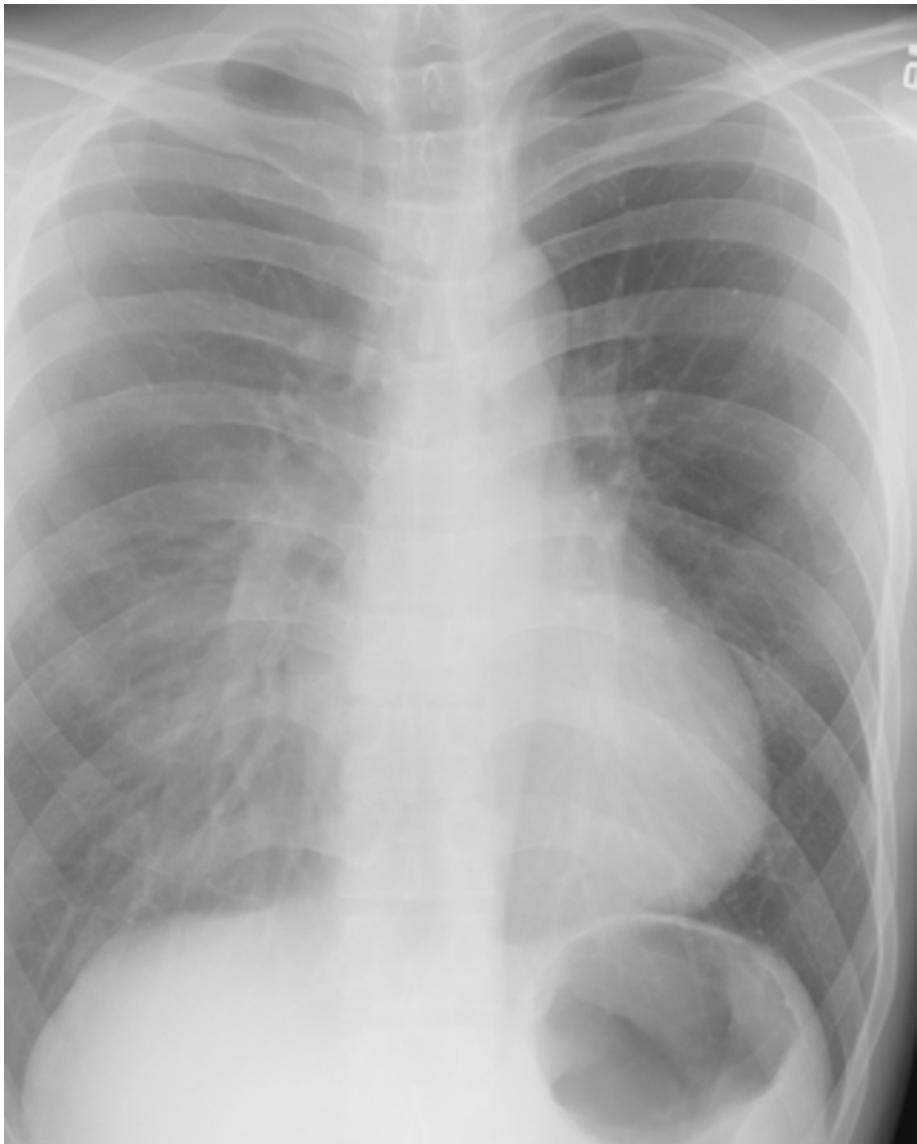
Frontal radiograph of the chest where the right costophrenic angle has been excluded. Often this will be the only location where small pleural effusions will be seen. When this region is left off of the film, these effusions may be missed.
